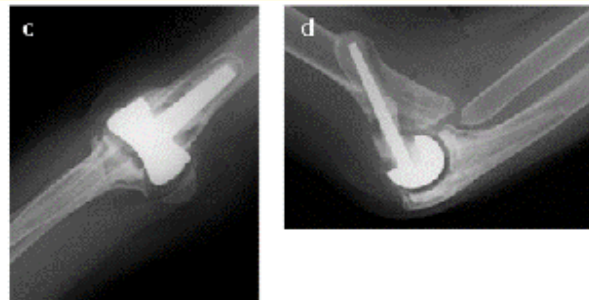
Plain radiographs before third revision TEA.
